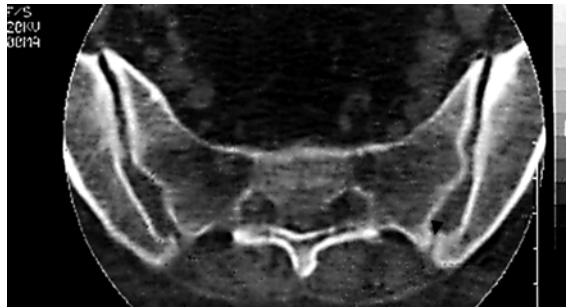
45-year-old woman with left accessory SJ (arrowhead) on a 5 mm CT section.
